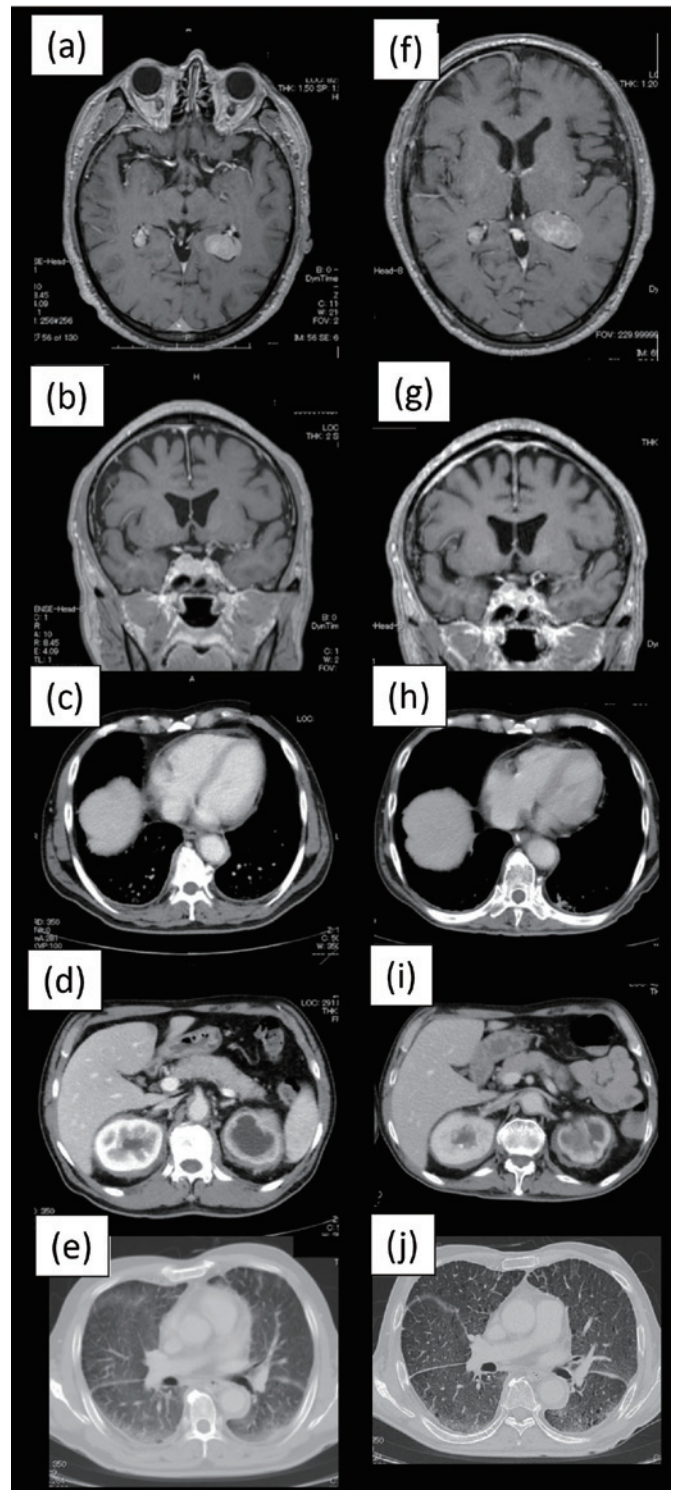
Magnetic resonance imaging (MRI) of the head, and computed tomography (CT) of the chest and abdomen at the time of diagnosis (a-e) and after treatment (f-j). (a, f) A left ventricular mass is observed. (b, g) Swelling of the posterior pituitary gland. (c, h) Abnormalities in the aorta wall. (d, i) Swelling is observed in both kidneys and the pancreas. (e, j) Ground-glass opacity is observed in both lungs. We judged the patient to have stable disease (SD) because there were no differences between the pretreatment and posttreatment radiographic findings.
